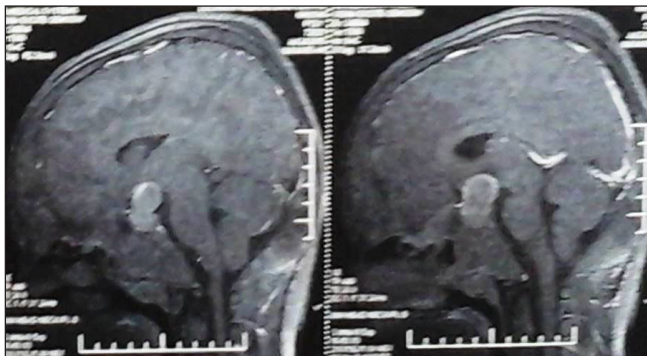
MRI brain sagittal T1 weighted post contrast images reveal heterogeneously contrast enhancing hyperintense sellar and suprasellar mass lesion extending superiorly up to the floor of the third ventricle and pushing the optic chiasma superiorly and anteriorly
